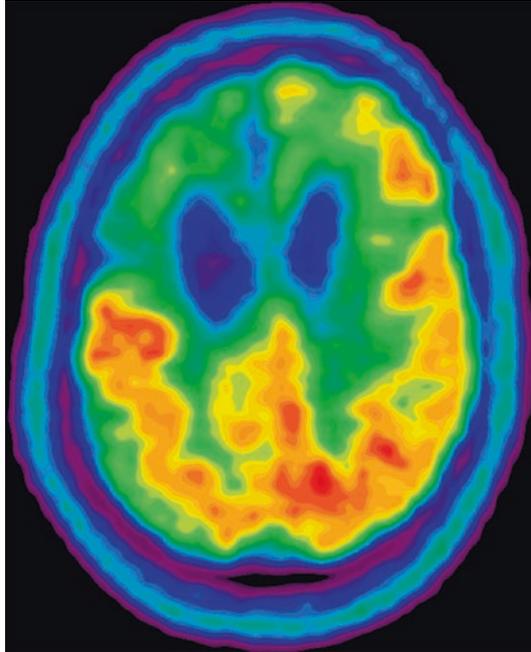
FDG-PET (*axial view*). Note profound hypometabolism involving anterior right frontal mesial, polar, and convexity
